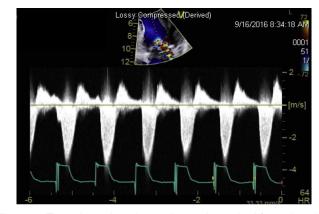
Transthoracic echocardiography, apical four-chamber view with continuous-wave and color Doppler across the mitral valve, demonstrating a dense, triangular, early peaking MR jet.
